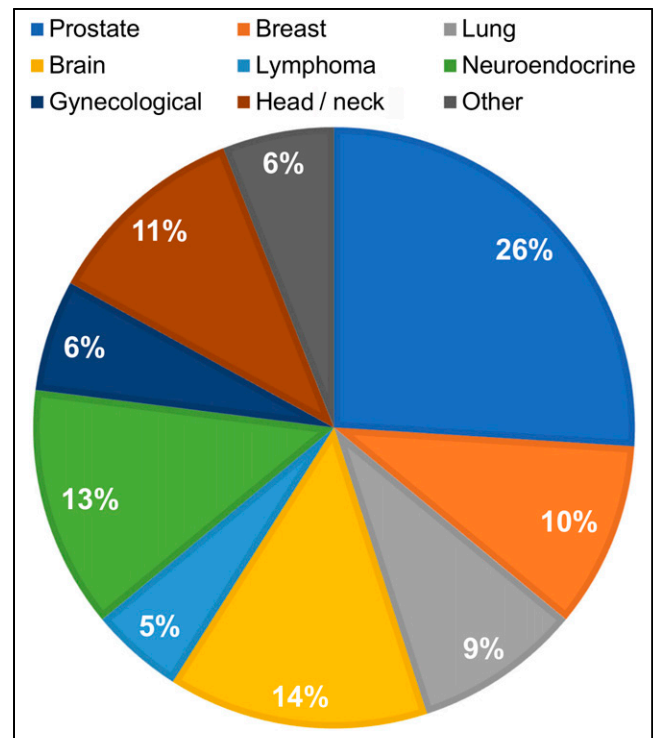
Yearly publication numbers for 2020 from PubMed for PET/MRI for various oncology applications suggest that prostate, brain, and neuroendocrine (including pancreatic) are most significant applications.
